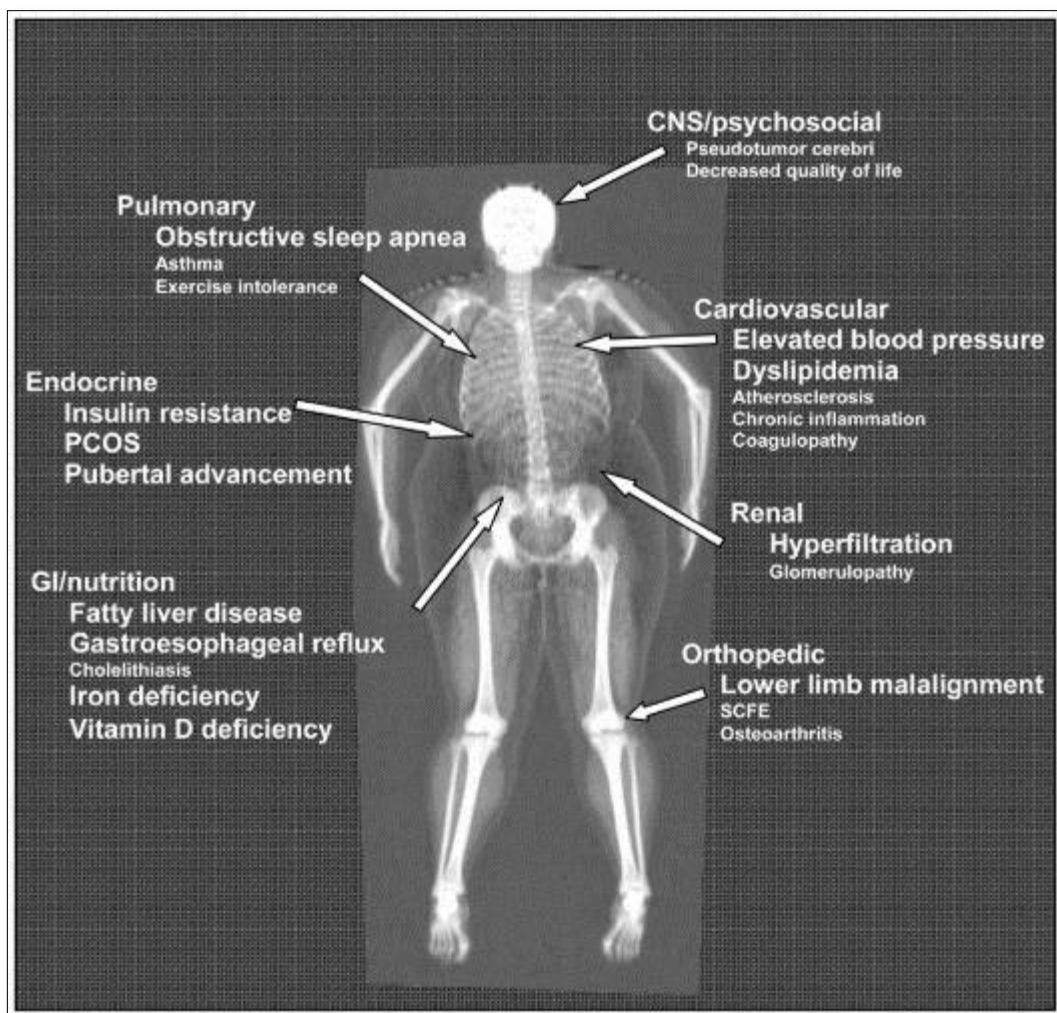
Image obtained by dual energy X-ray absorptiometry from a teenage girl with BMI 38 kg/m². Conditions that are of high prevalence and are well-established in their association with childhood obesity are shown in larger font size.
